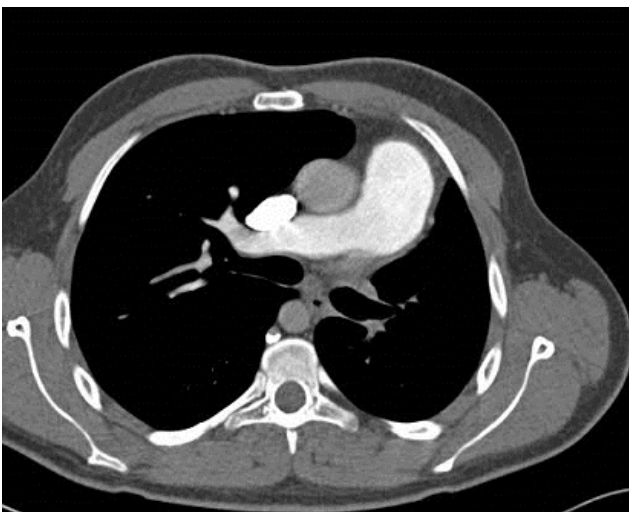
Pulmonary CT angiography revealed absence of left pulmonary artery at the bifurcation level (axial image).
